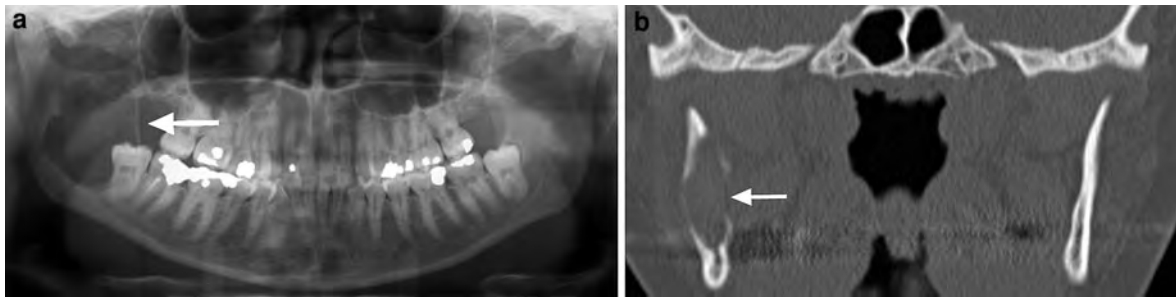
Benign intrinsic lesion of the right mandible in a 26-year-old male with subtle numbness of the right inferior alveolar nerve. a Panoramic radiograph reveals lobulated smooth osteolytic area (*arrow*) in the right mandibular ramus.
